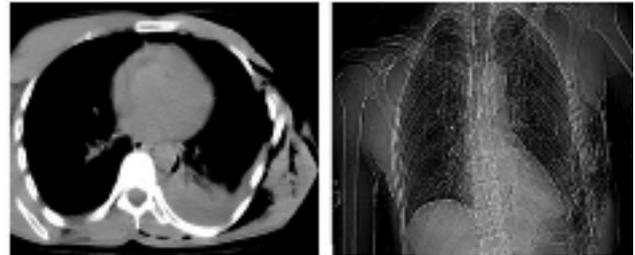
Rib fractures on Thorax CT and P-A Chest X-Ray
